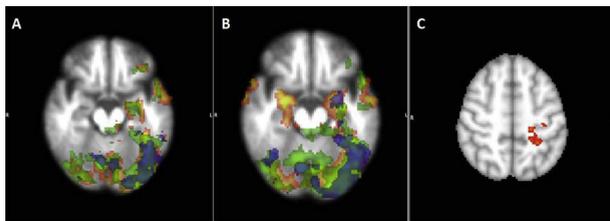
Brain activation maps (HC in orange, PIB- in green; PIB+ in blue; slice in Z = -16mm) before CT (A), after CT (B) and increased resting state connectivity (slice in Z=52mm) after CT (C) for HC in comparison to PIB+ and PIB- MCI participants between the right hippocampus and left superior parietal, pre and post-central gyri.
